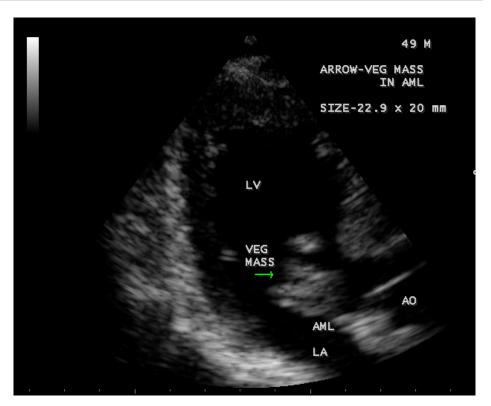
The vegetation is attached to AML-apical four chamber view in a 49-year-old febrile male.
